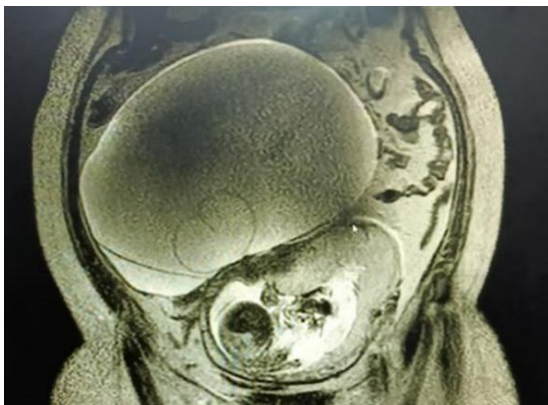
MRI depicting a thin-walled cystic mass with daughter cyst within and fetal head seen on coronal section.
